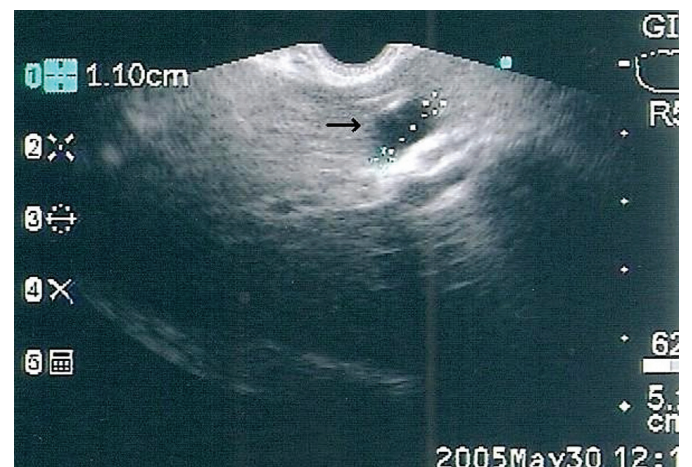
Endoscopic ultrasonography (EUS) demonstrating a duodenal hypoechoic mass (carcinoid tumor) (arrow) originating from the deep submucosa
